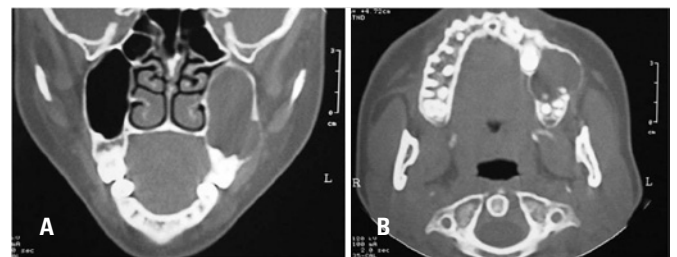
(A) Coronal computed tomography scan showing a large unilocular hypodense image in the left maxillary sinus. The lesion expanded to the maxilla, eroded the lateral sinus wall and spared the nasal cavity. (B) Axial computed tomography scan showing a hypodense lesion associated with buccal and palatal expansion. The small radiopaque portion in the distal part of the lesion, which is not detected on conventional radiographs
